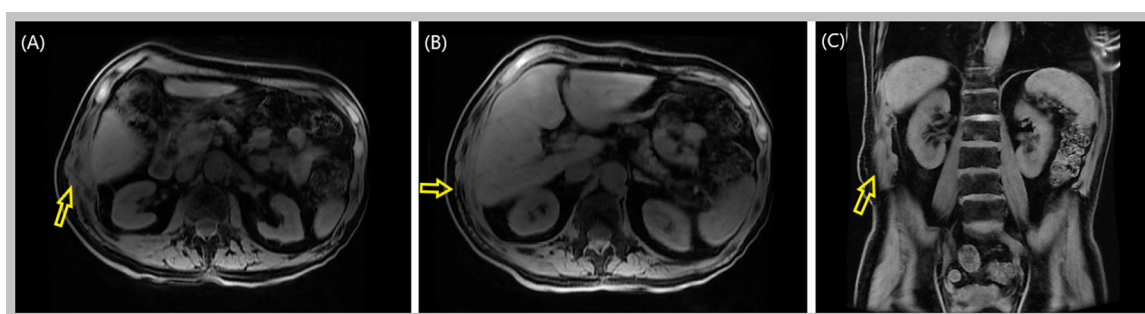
Magnetic resonance imaging. Interval appearing surgical drain crossing the right lateral abdominal wall (yellow arrow in [A]) with previously seen perihepatic abscess essentially resolved with only trace curvilinear hemorrhagic fluid in the perihepatic space and minimal curvilinear fluid. Also visualized is mild soft-tissue edema in the right lateral abdominal wall, however, almost resolved compared to the prior images (Color version of figure is available online).
